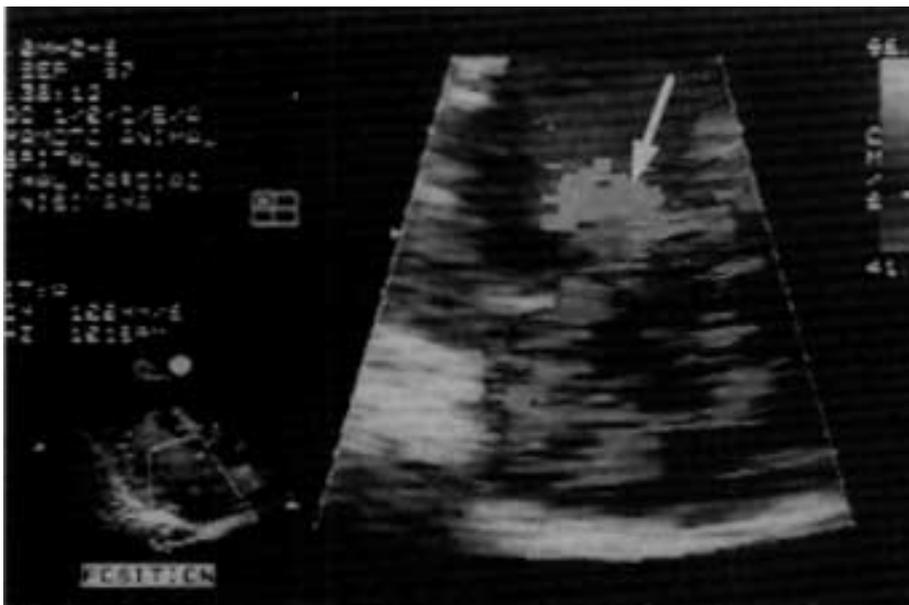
Color flow Doppler echocardiogram in the left parasternal long-axis view; At acceleration flow through leaking orifice set at aliasing velocity of 41 cm/s. It is indicated by arrow.
